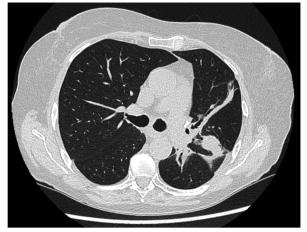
High-resolution chest computed tomography of the lung showing regression of the lesions and partial remission of the primary lesion
